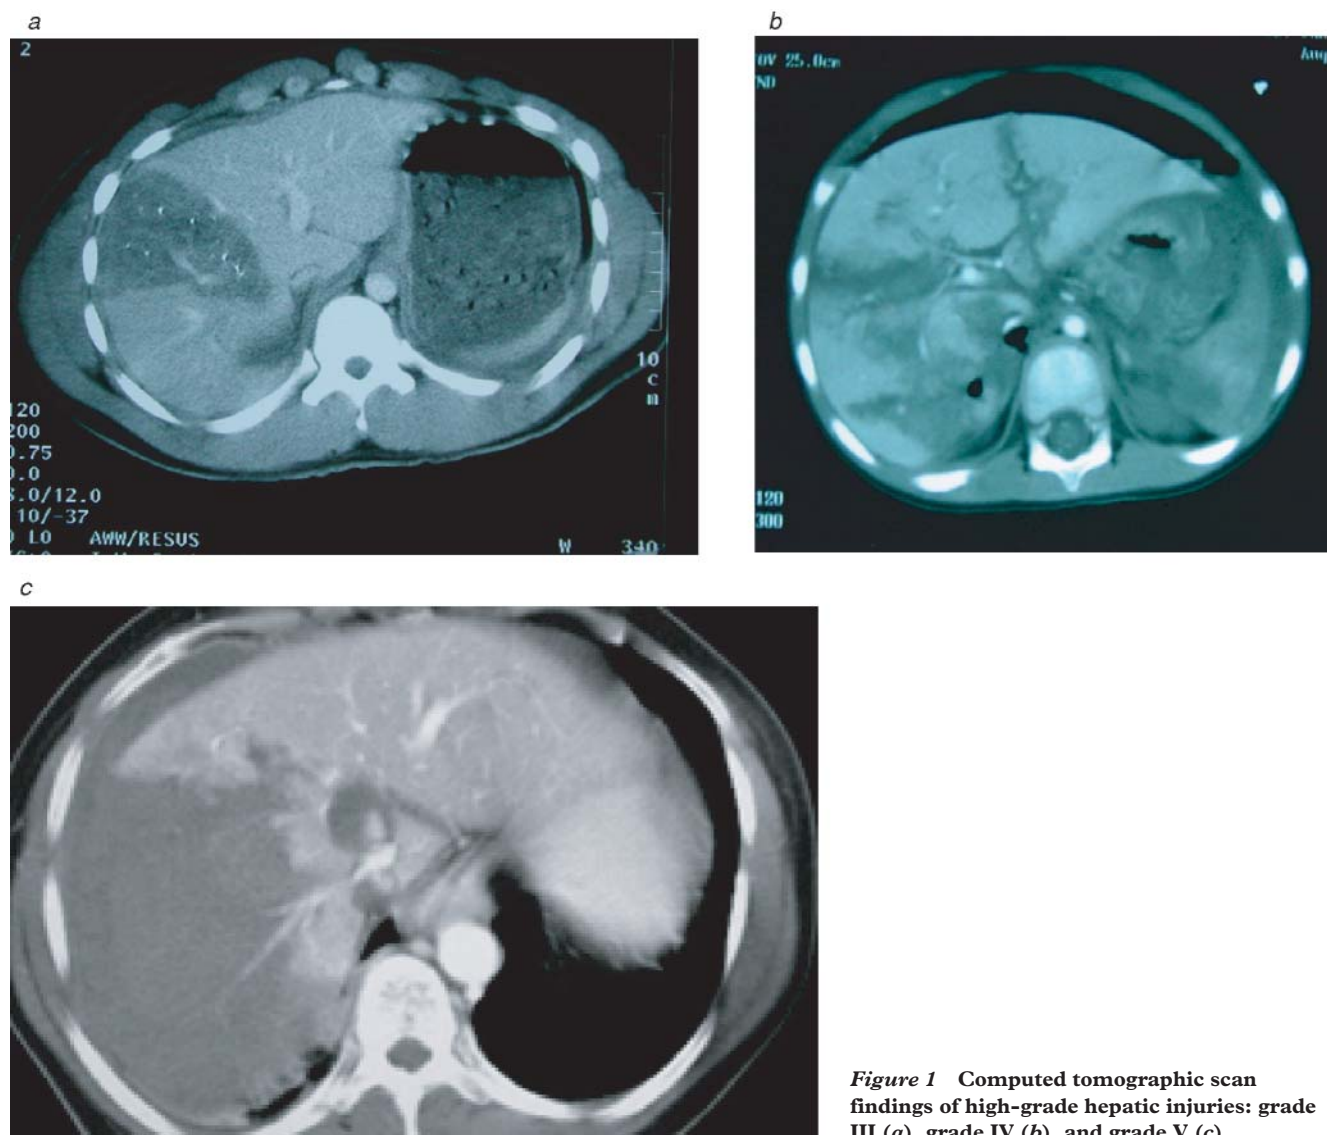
Computed tomographic scan findings of high-grade hepatic injuries: grade III (a), grade IV (b), and grade V (c).
